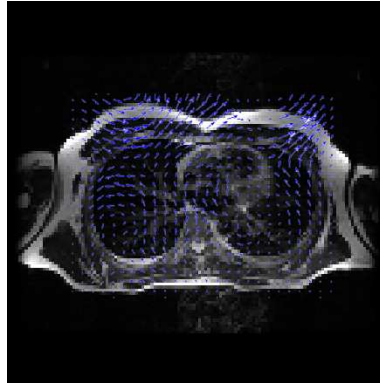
Axial slice number 10 of expiration MRI image. Displacement vector field is represented as vectors.
